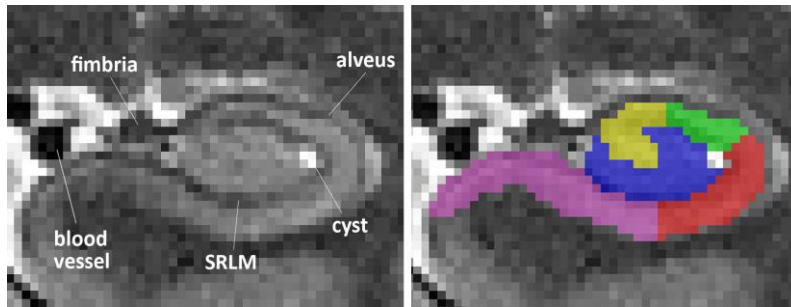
Excluded structures in a coronal view. Anterior hippocampal body slice from a T2 MRI scan including alveus, fimbria, SRLM, a blood vessel and a cyst in the ventrolateral flexion point of CA1 in the vestigial hippocampal sulcus. *SRLM, stratum radiatum lacunosum moleculare.*
